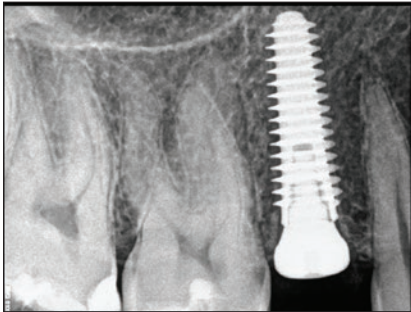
A periapical radiograph revealed excellent subcrestal positioning of the implant.
